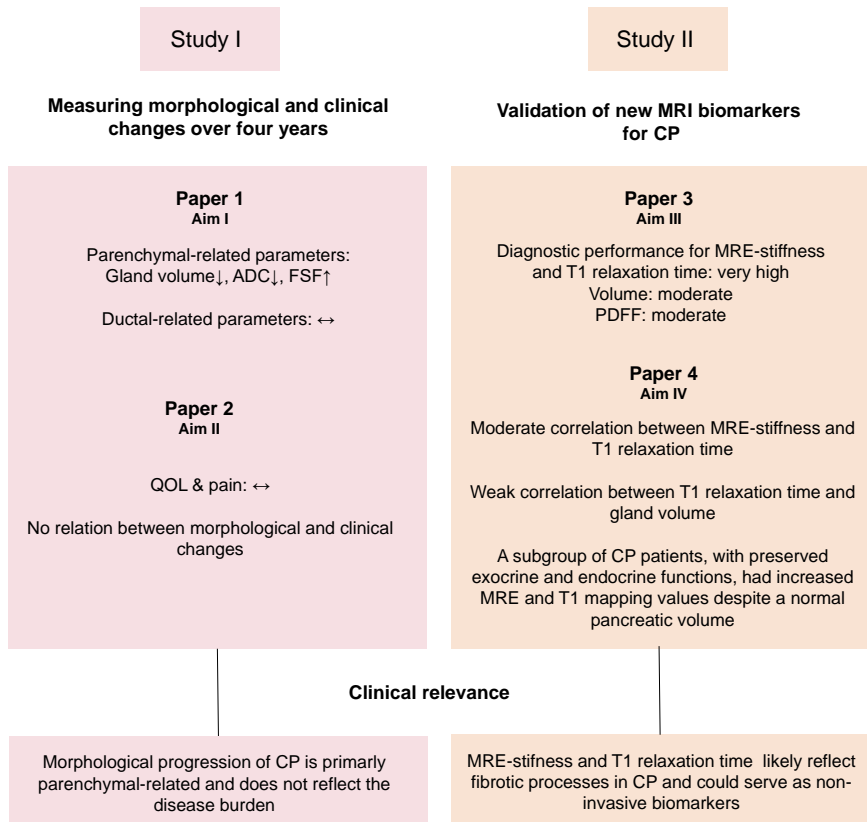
Overview of the main results from Paper I-IV. Abbreviations: CP, chronic pancreatitis; MRI, magnetic resonance imaging; ADC, apparent diffusion coefficient; FSF, fat signal fraction; QOL, quality of life; MRE, magnetic resonance elastography; PDFF, proton density fat fraction.
